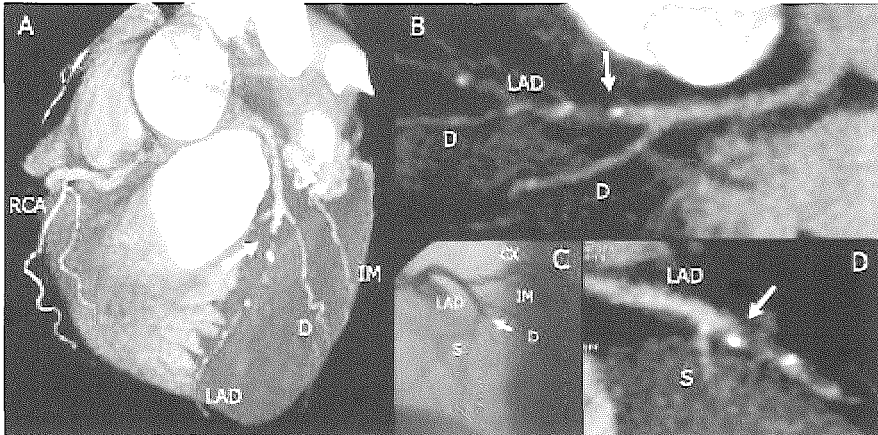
Occlusion of the left anterior descending coronary artery. Three dimensional reconstruction (A) and curved multiplanar reconstruction (B) of a CT coronary angiogram showing an occluded (arrow) left anterior descending coronary artery (LAD) (B), which was confirmed by conventional by conventional coronary angiography (C). A sagittal cross section shows in detail the different plaque components, both calcified and non calcified, as well as some residual contrast enhancement within the obstructed segment (D). Right coronary artery (RCA), diagonal (D), intermediate (IM) and circumflex branch (CX).
